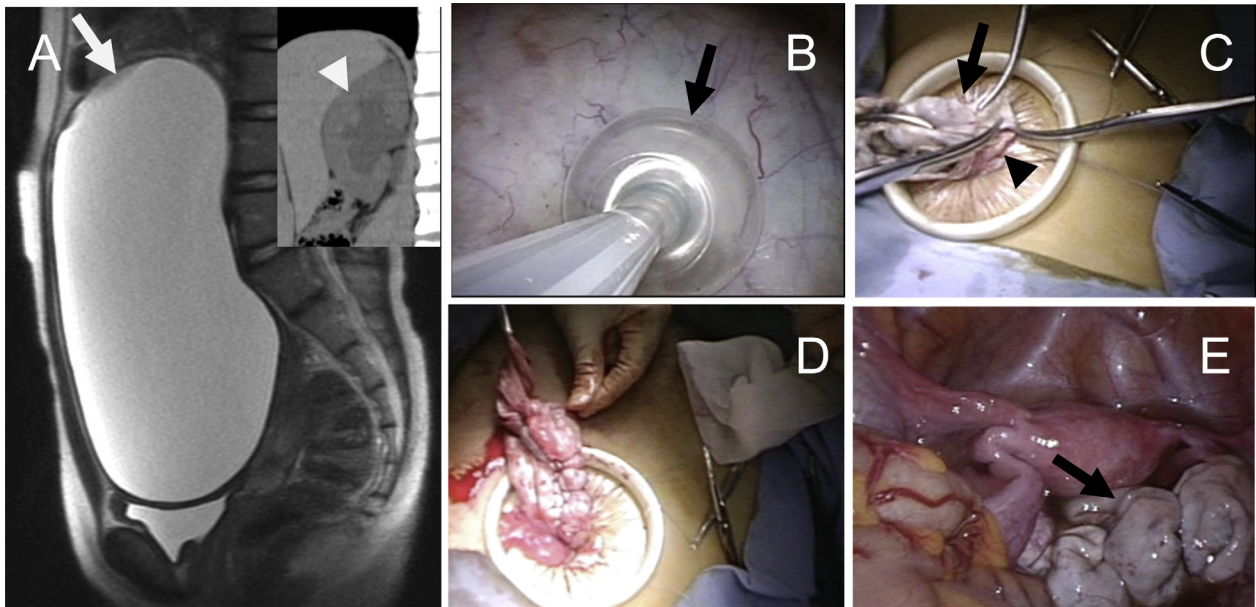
A 13-year-old girl received gasless laparoendoscopic single-site-assisted extracorporeal ovarian cystectomy for left dermoid cyst with left hydronephrosis after consultation due to abdominal distension. (A) Sagittal-view T2-weighted magnetic resonance image showing 22-cm left dermoid cyst with sagittal-view reconstituted computerized tomographic image showing left hydronephrosis (inset, arrow). (B) Under laparoscopic guidance, the cyst wall was punctured utilizing a SAND balloon catheter (Hakko Medical, Tokyo, Japan), which has two balloons at the tip of the needle to minimize spillage of cystic contents during aspiration. (C) After maximal removal of the cystic contents, left adnexal tissue was completely exteriorized through the umbilical port with gradual termination of abdominal-wall lifting and the ovarian cyst (arrow) was enucleated from ovarian parenchyma (arrowhead). (D) The ovarian parenchyma was extracorporeally reconstructed with surgical instruments for abdominal procedures. (E) The left adnexal tissue (arrow) was returned to the abdominal cavity for final inspection of hemostasis. Excised tissue weight including the cystic contents was 2062 g and the surgical duration was 97 min. Intraoperative blood loss was 50 mL. Postoperative course was uneventful and she was discharged on postoperative day 3.
